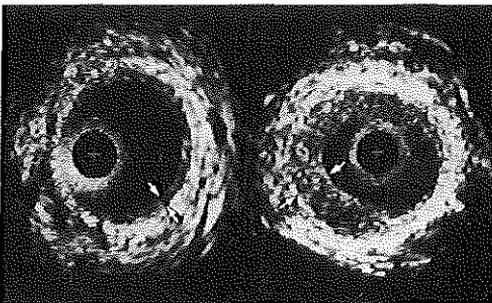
Intravascular ultrasound cross-sections showing a normal venous bypass (left panel) and a venous bypass with thickening of the vein wall (right panel). + = Catheter; calibration = 1 mm.
